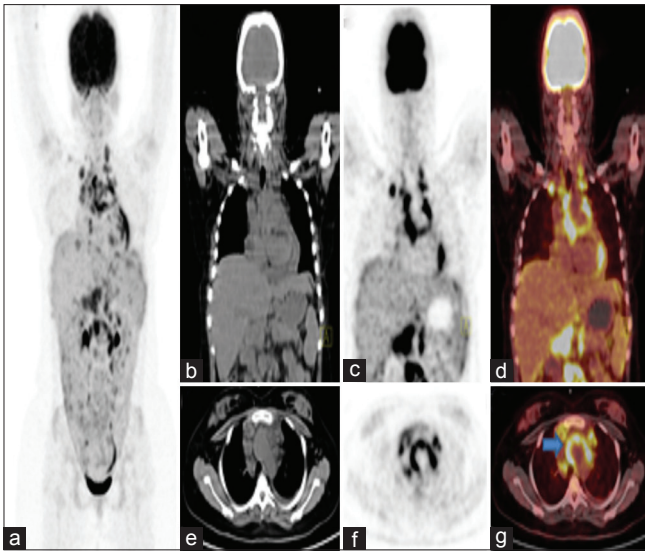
Case 1 - Maximum intensity projection image (a) showing linearly increased fluorodeoxyglucose uptake in mediastinum. coronal (b-d) and axial (e-g) sections of computed tomography, positron emission tomography and fused positron emission tomography-computed tomography images showing increased fluorodeoxyglucose uptake in aortic wall with maximum standardized uptake value: 11.3 (liver maximum standardized uptake value: 2.8)
